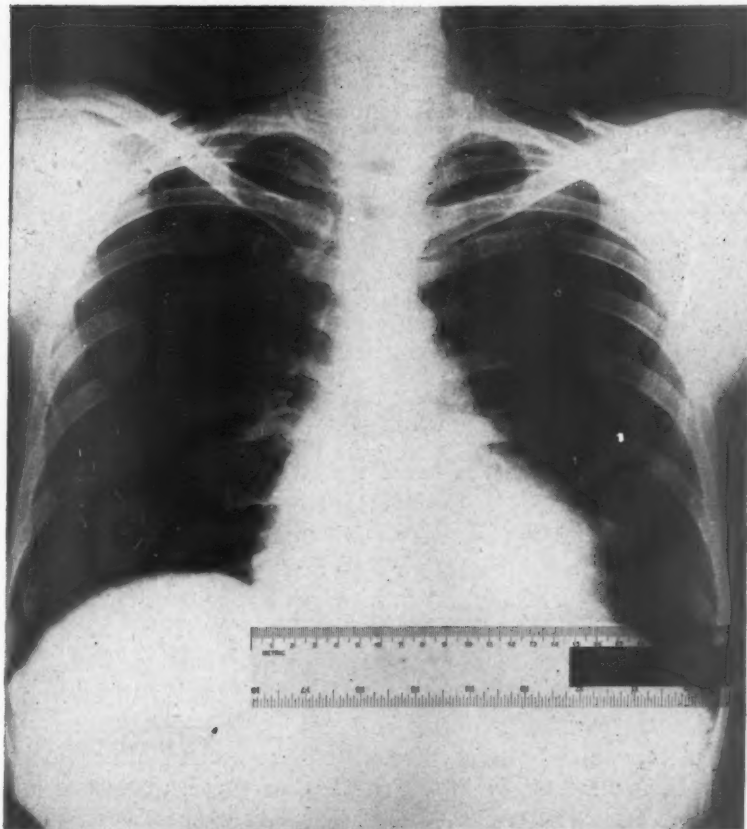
Roentgenogram of the heart after treatment.
